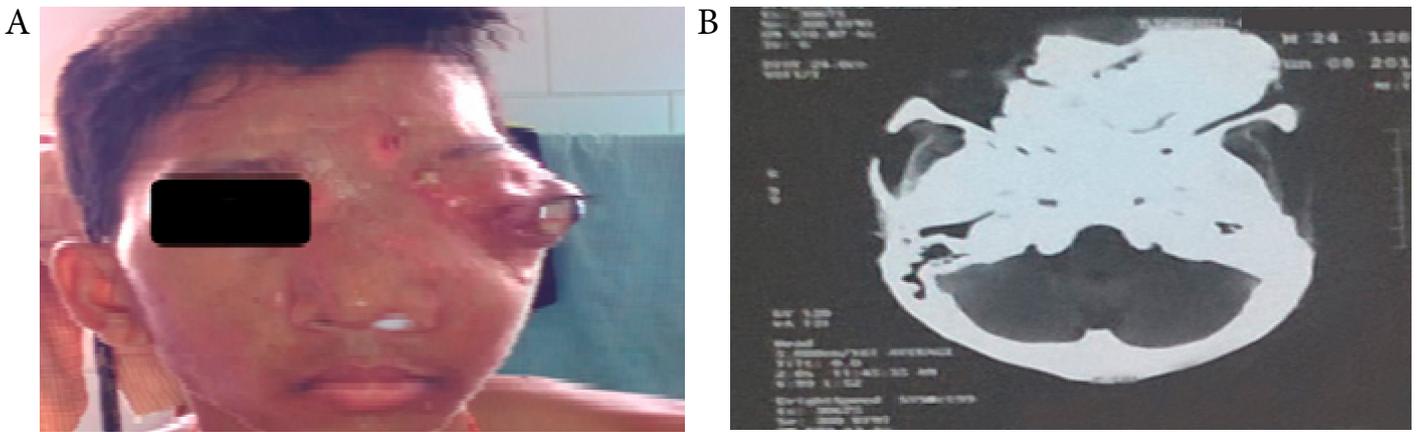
(A) Clinical picture and (B) CT scan of PNS, axial view of fibrous dysplasia.
